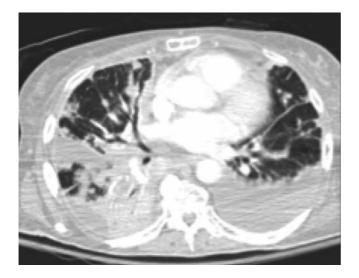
Chest CT image demonstrating multiple pulmonary nodules, compressive atelectasis and associated bilateral pleural effusions.
